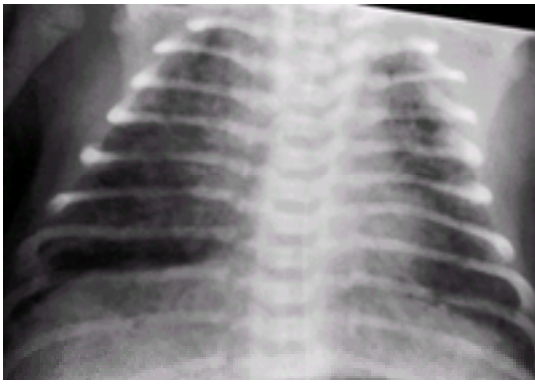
Meconium aspiration radiograph.
